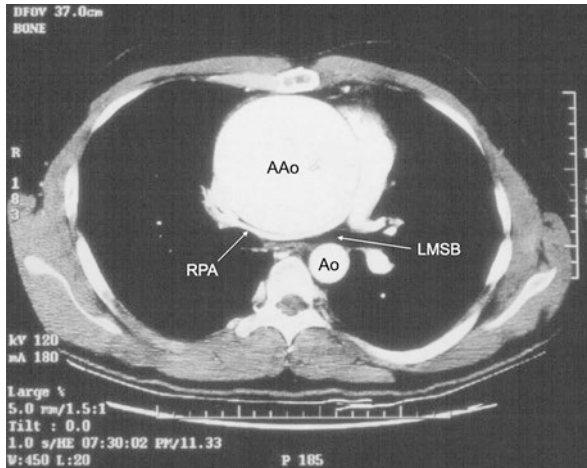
Computed tomographic angiography (CTA) axial cross section at the level of the tracheal carina in a patient with a dilated ascending aorta (AAo) causing simultaneous compression of the pulmonary artery and airway that places the patient at risk of respiratory failure from airway obstruction, hypoxemia from ventilation/perfusion mismatching from obstruction of the right pulmonary artery (RPA) together with the left mainstem bronchus (LMSB), and heart failure from right ventricular outflow tract obstruction in response to the induction of general anesthesia
